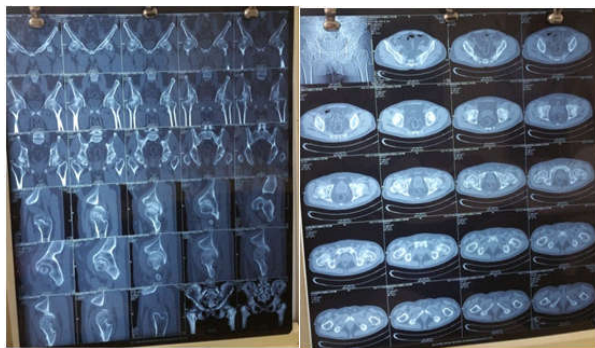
Pre-Op CT Scan of pelvis with both hips
